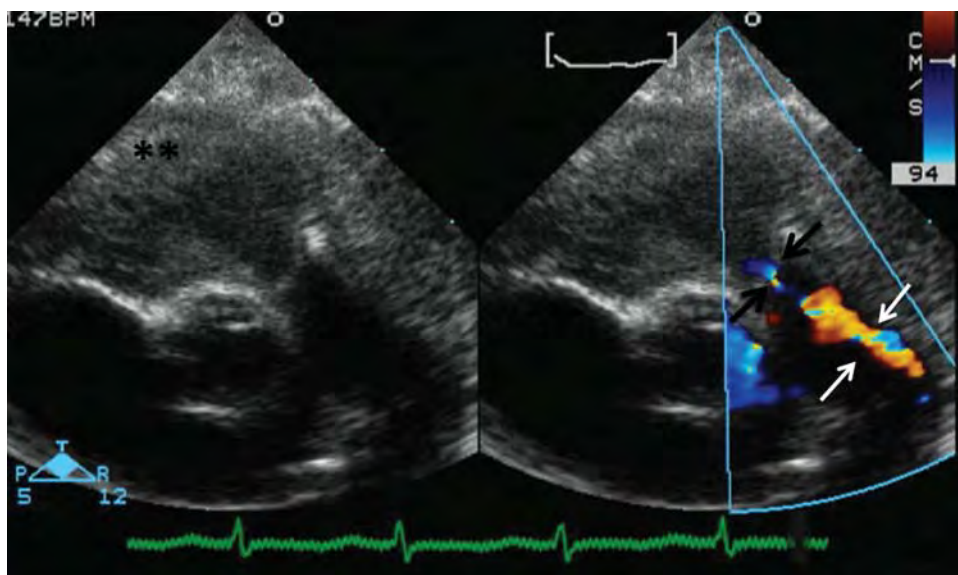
Parasternal short-axis transthoracic echocardiographic image taken in end-systole with and without color Doppler. Two-dimensional and color Doppler imaging across the right ventricular outflow tract demonstrate a patent infundibular region with poorly mobile pulmonary valve leaflets and a narrow jet of flow exiting through this critically stenotic valve (black arrows). Also seen is the left to right shunt via a patent ductus arteriosus which serves as this neonates primary source of pulmonary blood flow at this point in time (white arrows).
